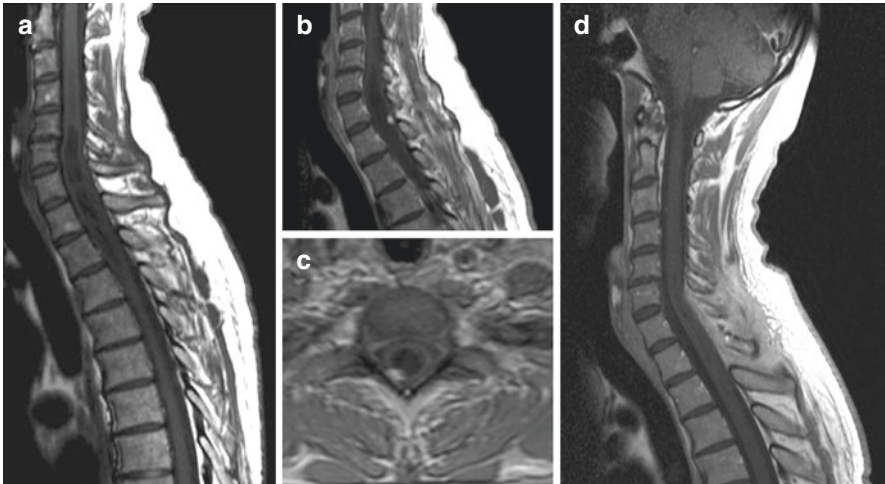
(a) This T1-weighted MRI image of a 56-year-old man shows a syrinx between C5 and Th3. (b) After gadolinium application a small angioblastoma appears posteriorly at C7/Th1. The corresponding axial scan demonstrates the typical location of this tumor in the posterior root entry zone on the right side (c). (d) With removal of this tumor, the syrinx collapsed
